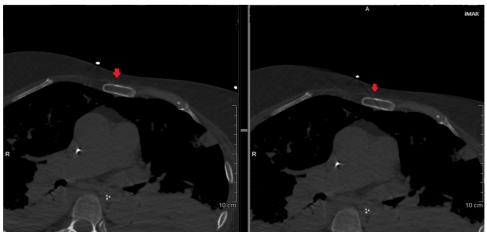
Thoracic CT scan. Left: unreconstructed image. There are no artifacts despite the presence of an external metal cable laterally to the patient's sternum. Right: reconstructed MAR image. There is a primary artifact represented by a hypodense band that interrupts the cortical bone.
